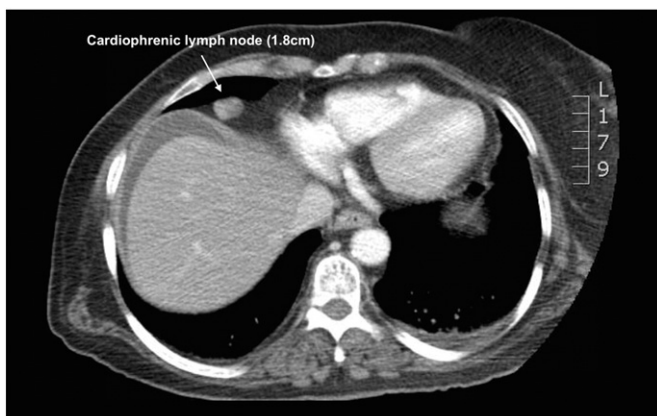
Pre-operative CT scan demonstrating enlarged cardiophrenic lymph node in mediastinum.
